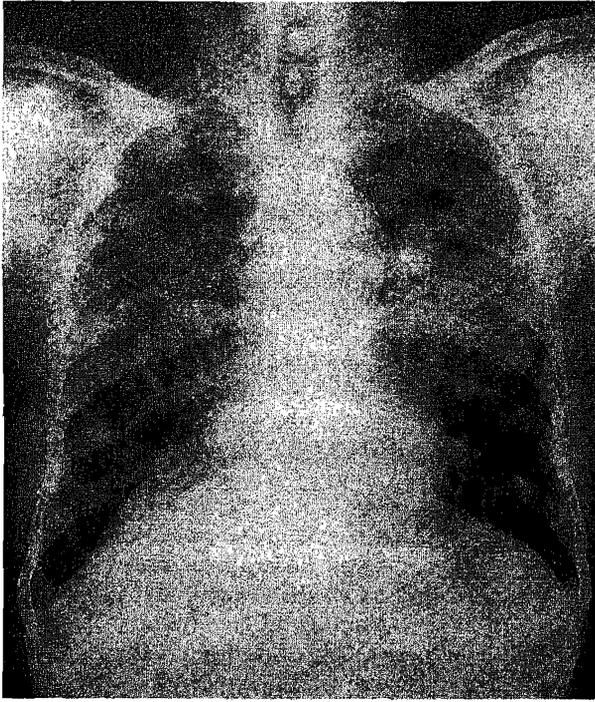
Chest roentgenogram demonstrating extensive fibrosis, with confluence in the mid-lung fields.
